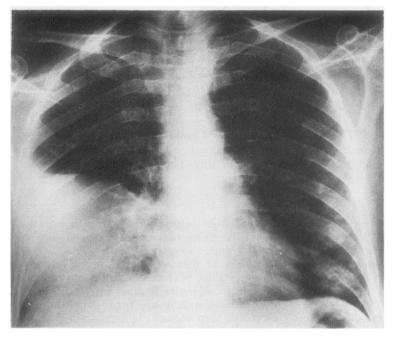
Chest radiograph demonstrates homogenous opacity of the right middle lobe and a patchy opacity at the left lower lobe.
